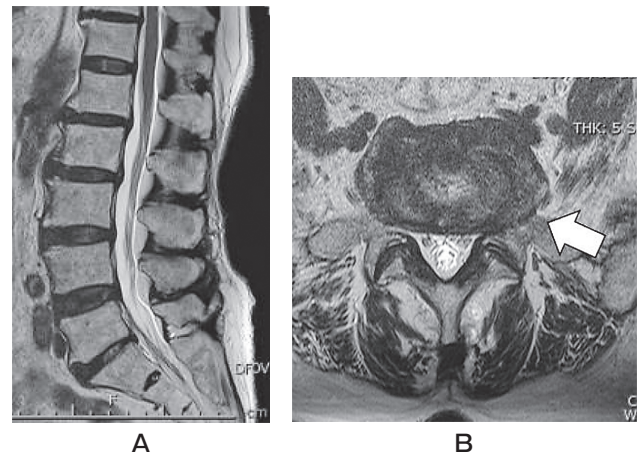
A, A preoperative magnetic resonance imaging (MRI) sagittal section shows no central stenosis; B, A preoperative MRI axial section demonstrates left L5-S1 foraminal and extraforaminal stenosis (white arrow).
